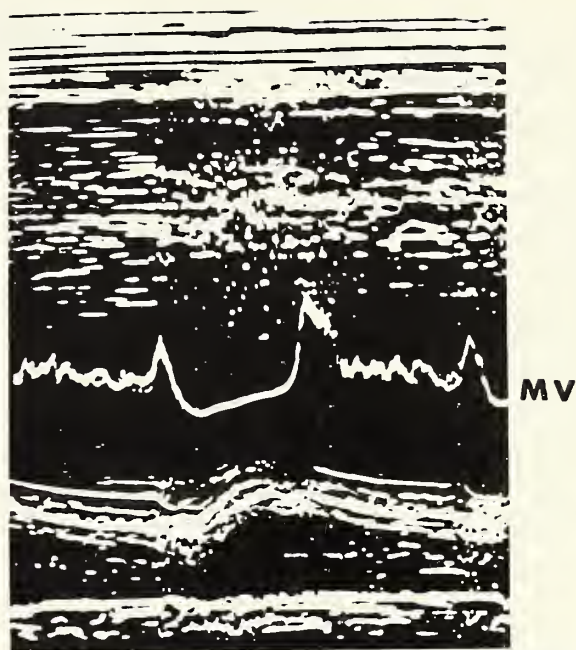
Echocardiogram showing the characteristic fluttering of the anterior mitral valve leaflet observed during diastole in many patients with aortic insufficiency and Austin Flint murmur.
